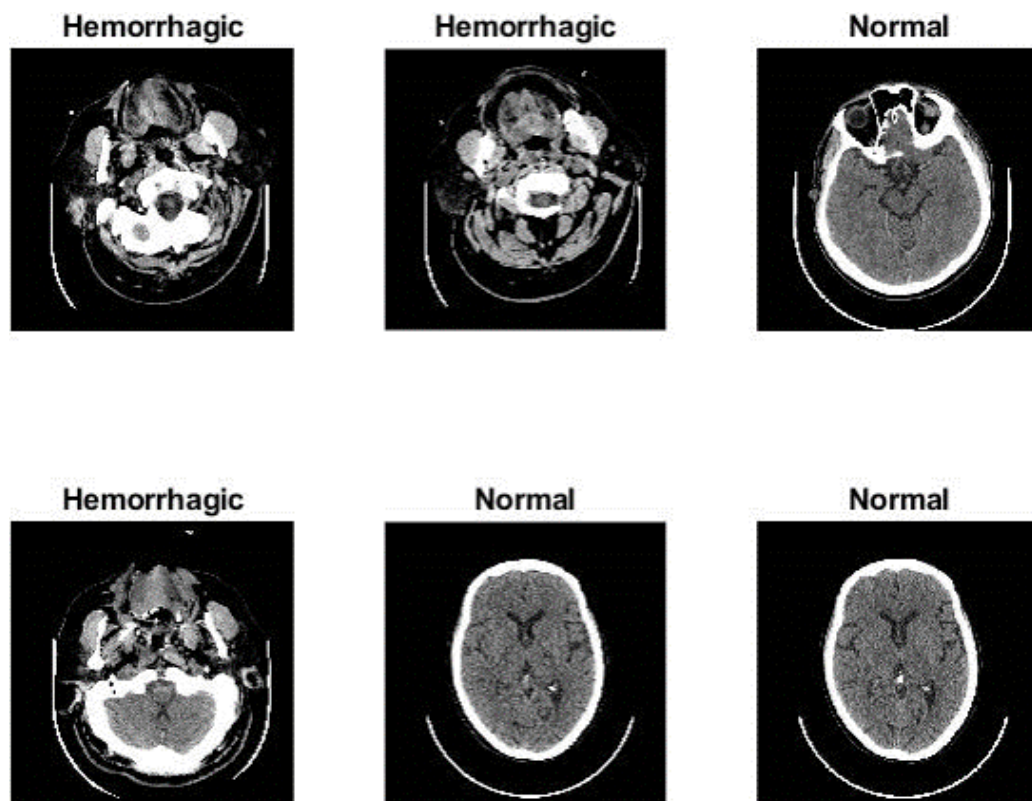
CT samples for the hemorrhage dataset.
